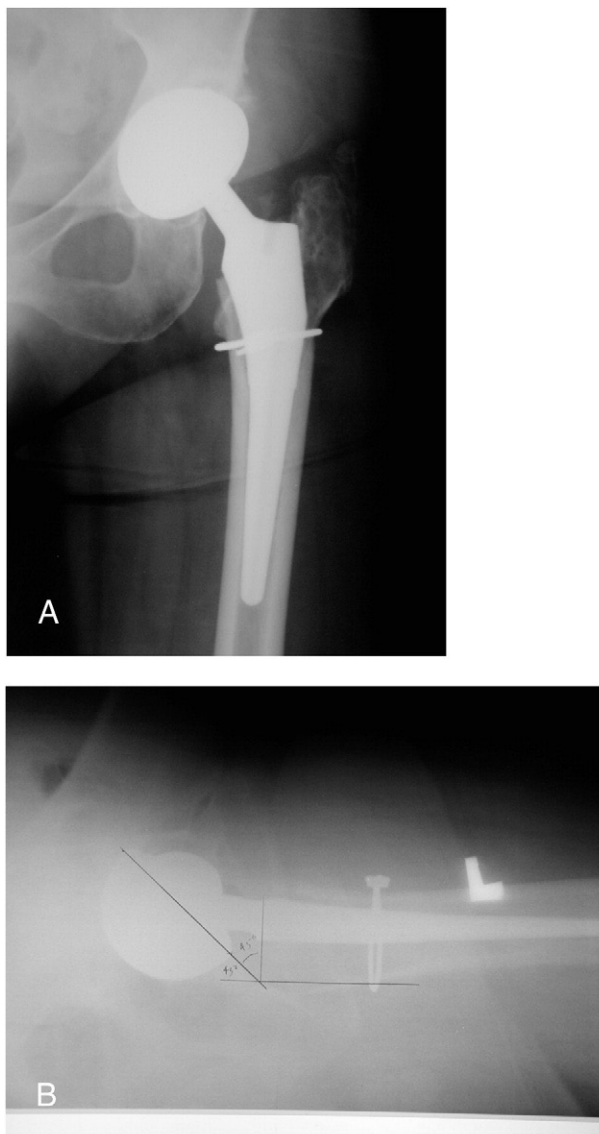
(A) Anteroposterior radiograph of the left hip, showing acetabular inclination of approximately 45°. (B) Cross-table lateral of the left hip showing excessive radiographic anteversion of 45°.
